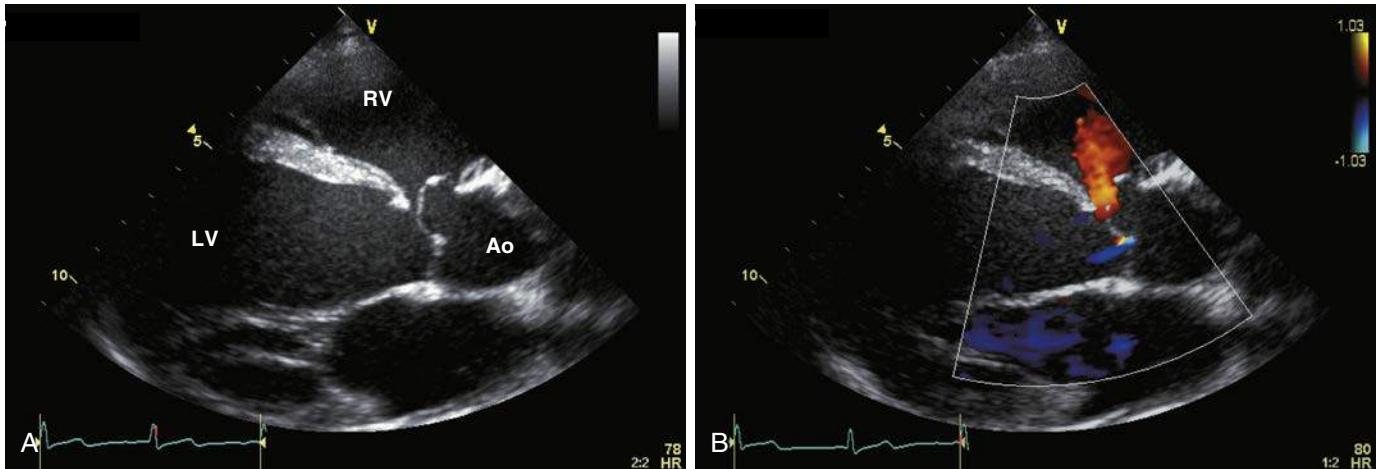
A, Parasternal long axis view of a perimembranous ventricular septal defect (VSD) with aortic valve prolapse. B, During systole there is a left to right shunt through the VSD that creates a Venturi (suction) effect on the right coronary cusp of the aortic valve. The VSD is partially occluded by the prolapsed cusp and aortic regurgitation occurs (demonstrated by colour flow imaging; B). The patient was referred for surgery.
